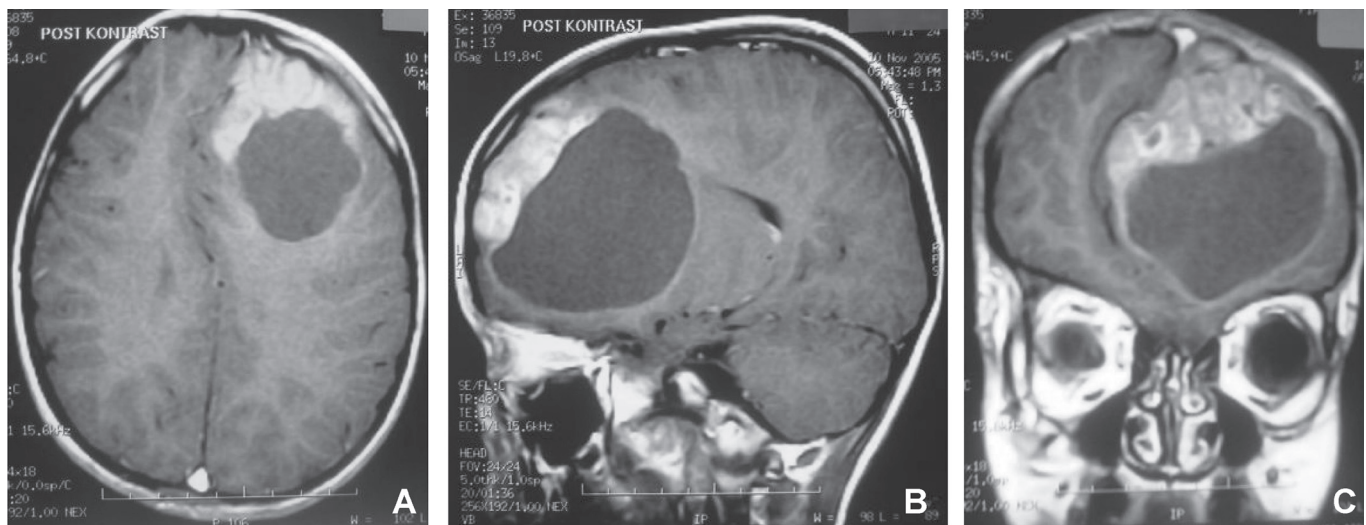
Preoperative axial, sagittal and coronal magnetic resonance images of the brain, showing a large left frontal cortical tumor associated with massive calcification and cyst formation.
